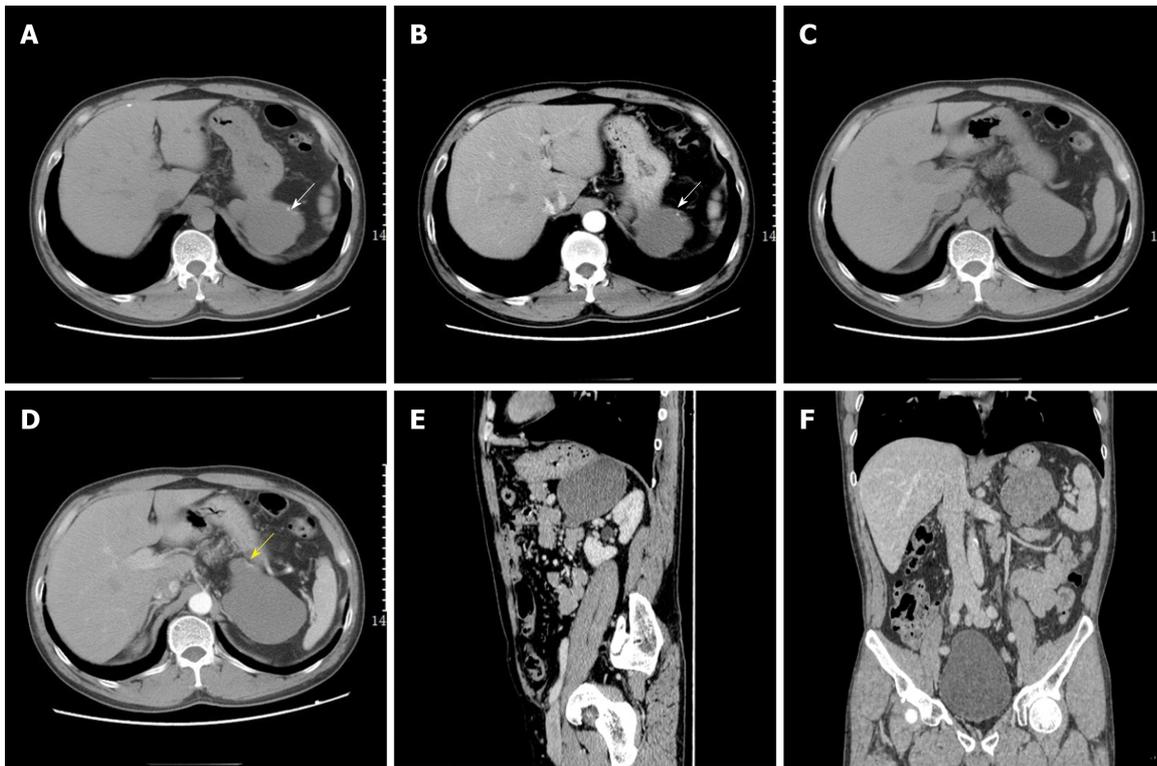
Contrast-enhanced computed tomography images of the gastric duplication cyst. A-F: A large cystic hypodense focus was along the greater curvature of the stomach, measuring 95 mm × 61 mm × 66 mm; A and B: The focus was lobulated and well-circumscribed with a small amount of calcification on its wall (white arrow); C and D: A nutrient vessel from the stomach on the cyst wall was observed on arterial phase images (yellow arrow).
